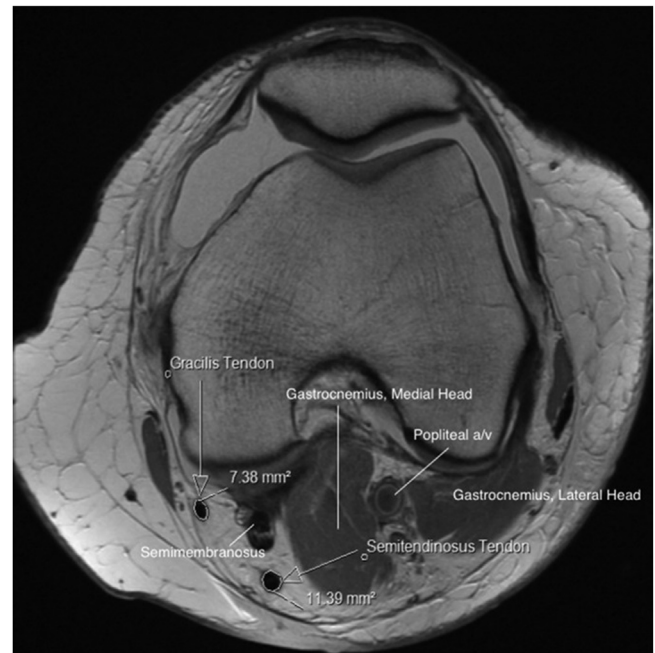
MRI axial image of a left knee demonstrating the technique used for measuring the cross-sectional area at the widest level of the femoral condyle (reproduced from Grawe et al.¹⁸).
